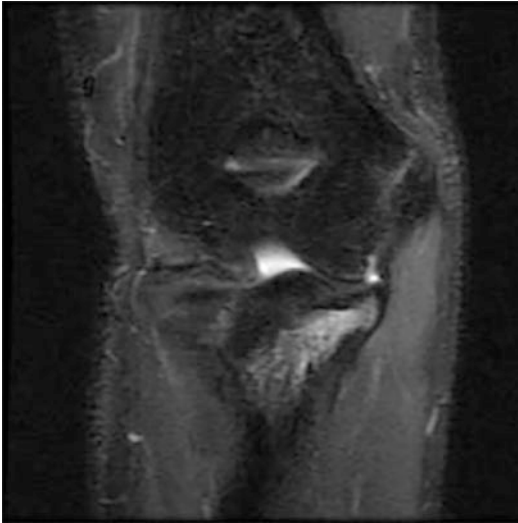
Proton-density sequence MRI of a 15-year-old pitcher and catcher with medial elbow pain. Note that the ulnar collateral ligament is intact, but there is significant bony edema and separation at the medial epicondylar apophysis
